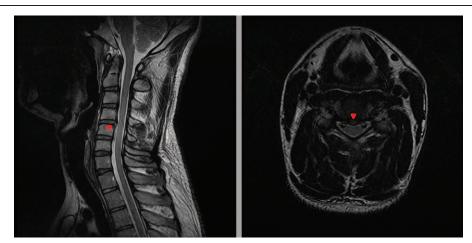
Sagittal and axial T2-weighted cervical spine magnetic resonance imaging at 1 year after pain onset showed central disc protrusion and a high-signal intensity zone at C4–5 (red arrow heads).
